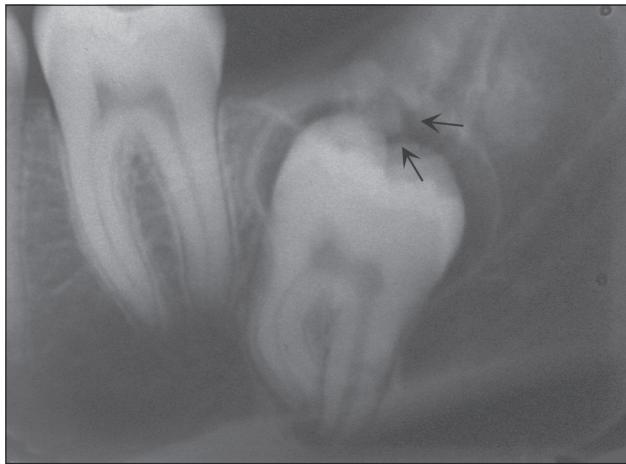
In the periapical view, 2 discrete globular opacities can be observed pericoronally, within the follicular space. The roots of the tooth are fully developed and dilacerated with apparent closure of the root apices.
